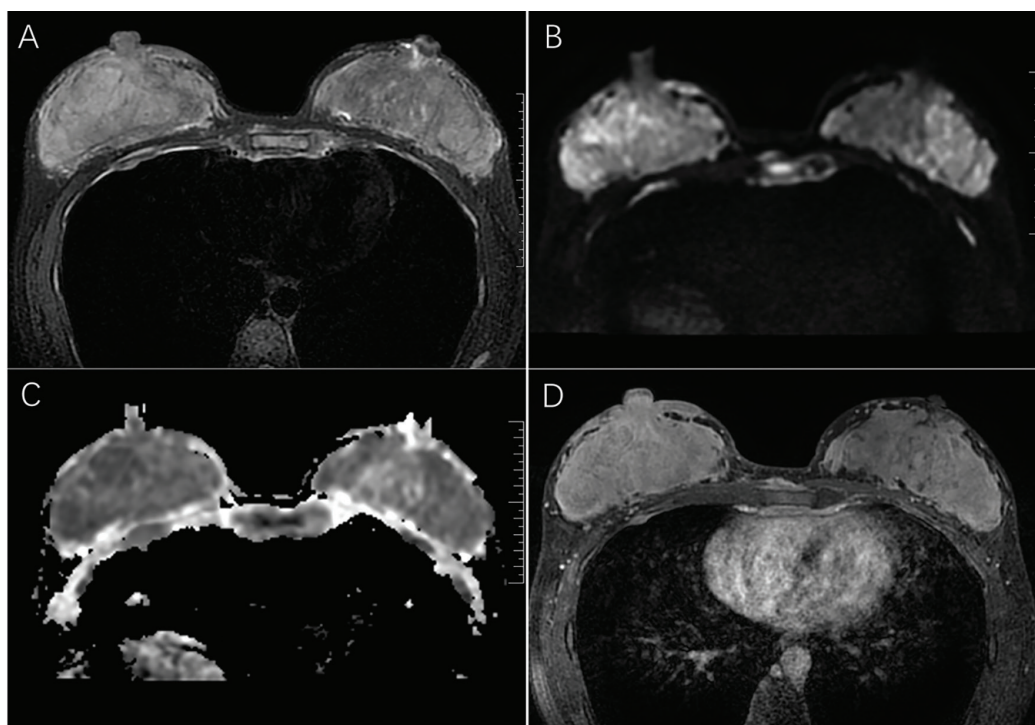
Breast magnetic resonance imaging examination, (A) T2-weighted fat-suppressed imaging shows diffuse high signal intensity in both breasts, (B) Diffusion-weighted imaging shows diffuse high signal intensity in both breasts, (C) The apparent diffusion coefficient map shows reduced signal intensity in both breasts, (D) Post-contrast imaging demonstrates heterogeneous enhancement, with skin thickening and enhancement in both breasts.
